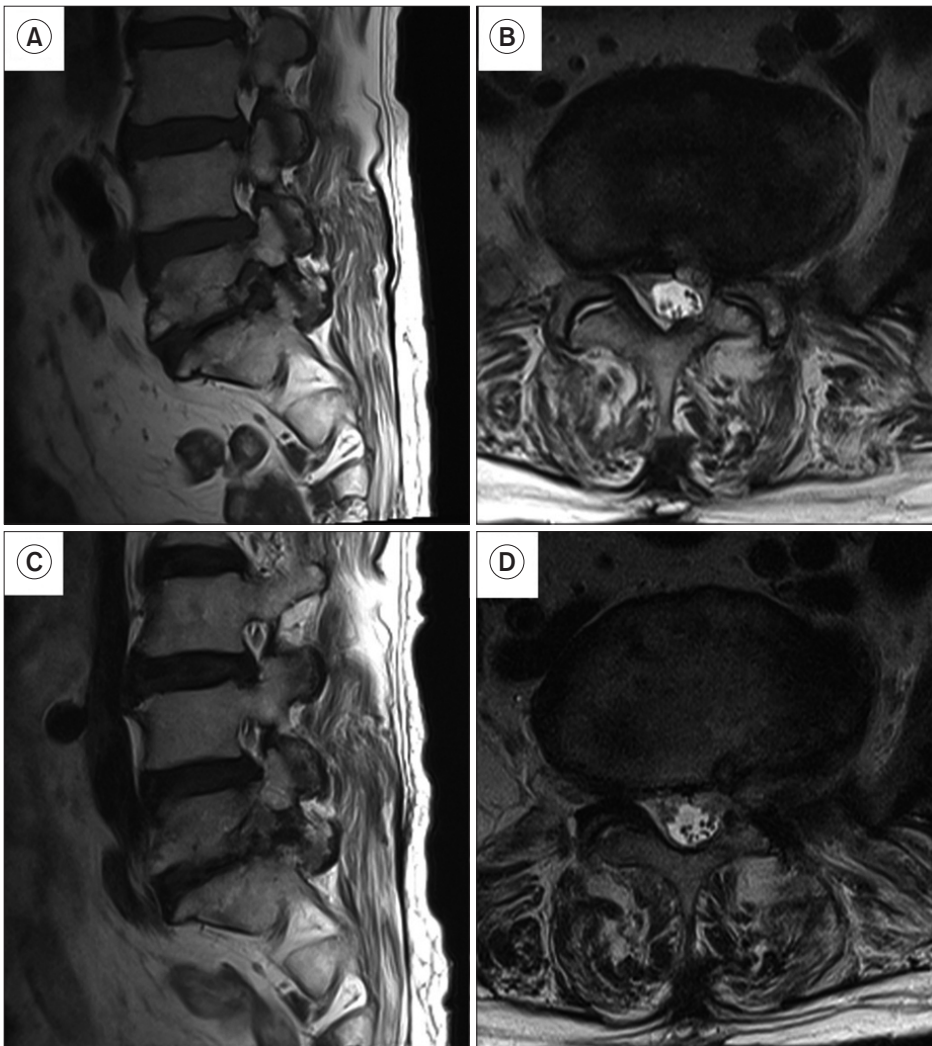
Magnetic resonance images of one patient. (A) Preoperative parasagittal T1-weighted image of the left foramen. Note the compression of L5 nerve root. (B) Preoperative axial T2-weighted image. (C) Postoperative parasagittal T1-weighted image showing widened foraminal space for L5 nerve root. (D) Postoperative axial T2-weighted image. Note the removal of superior articular process and relatively widened left foraminal space.
